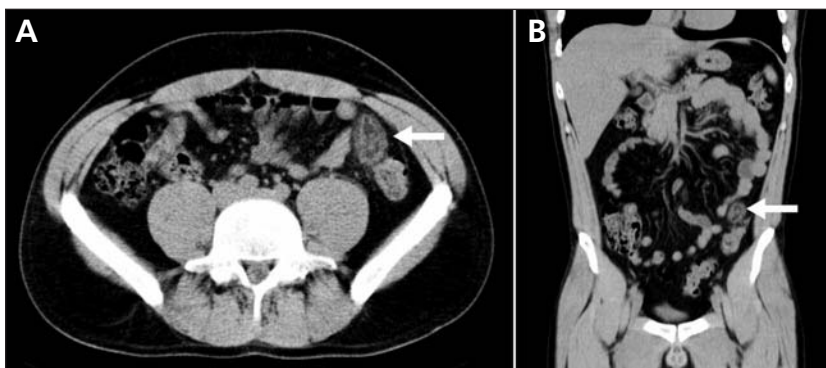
Computed tomography of the abdomen of a 33-year-old man with left flank pain. (A) The axial view shows an oval-shaped, paracolic mass with the density of fat (arrow). (B) The frontal view shows a paracolic mass with thickened peritoneal lining and periappendiceal fat stranding (arrow).
